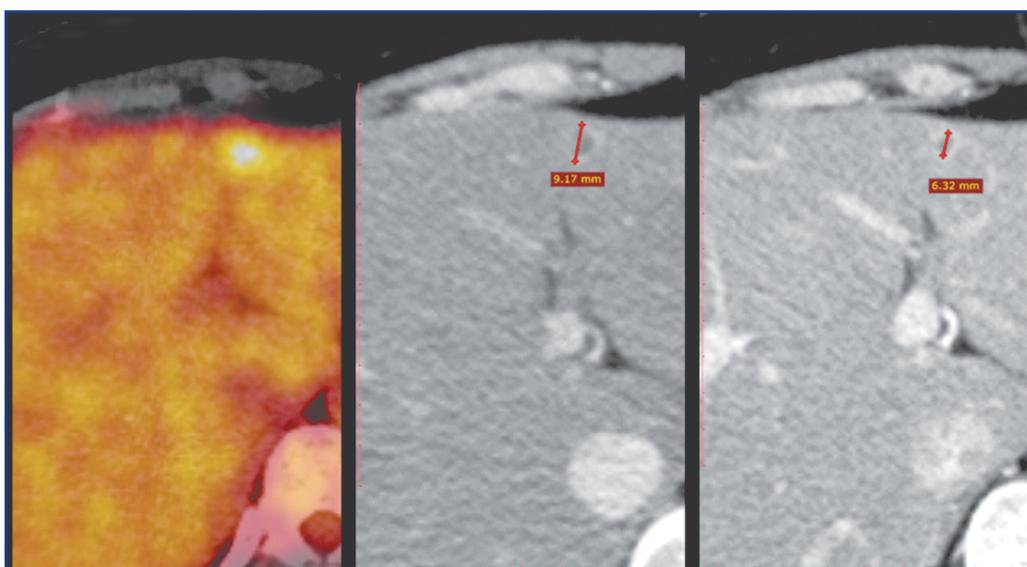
Thoracic Region CT with bolus contrast from October 2018 compared with data of July 2018 and PET/CT of March 2018. Residual mass in the liver - 0.6 cm.
